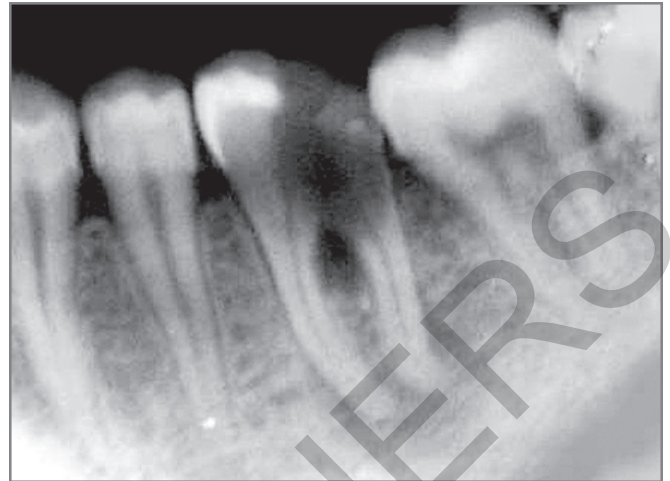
Loss of bone density seen in periapex of the tooth due to chronic periapical infection.
